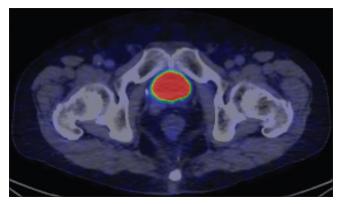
Fused axial image of the prostate bed on gallium-68 prostate-specific membrane antigen positron emission tomography/ computed tomography
